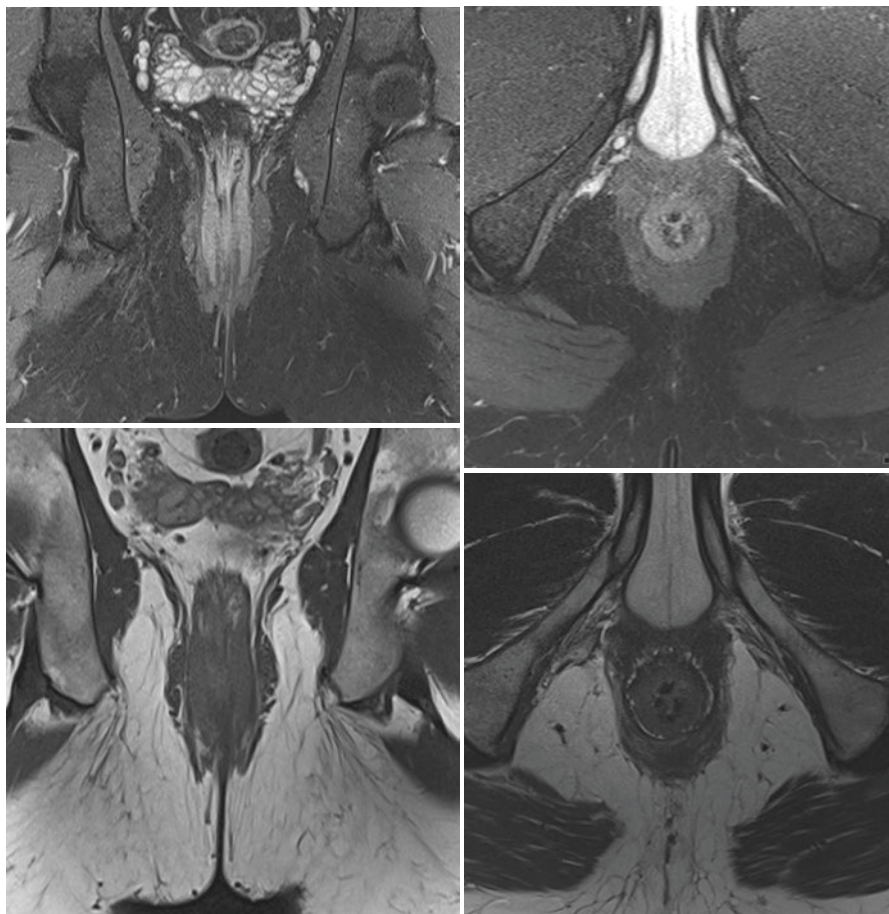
Proton density fat suppression and T2-weighted coronal and axial images of normal anal sphincter muscle complex
